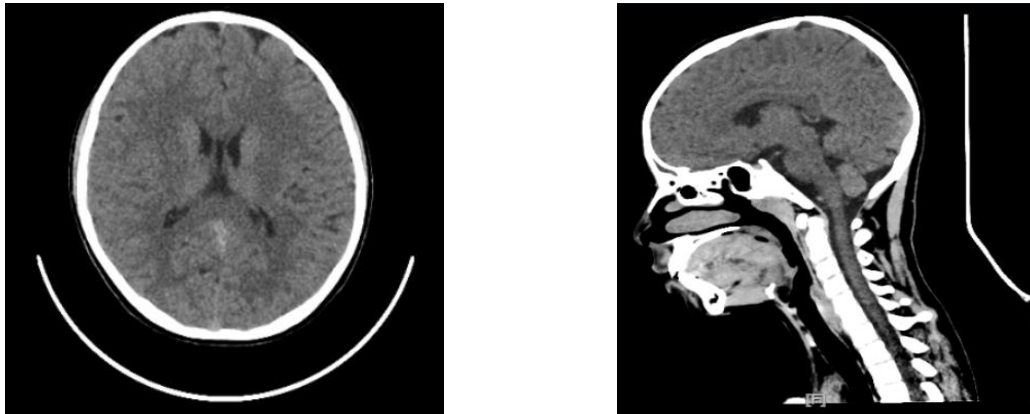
Head and Neck CT Scan Results without Contrast
